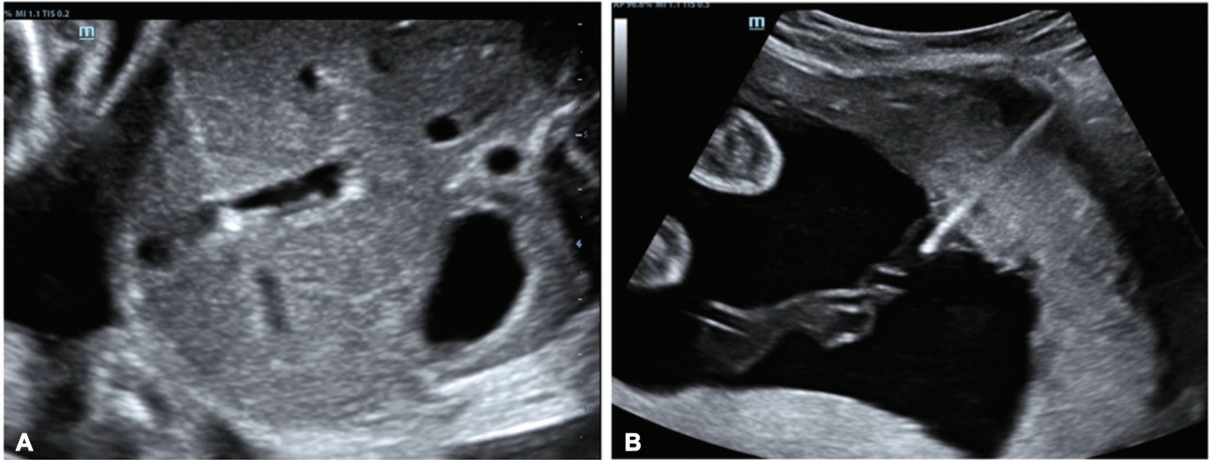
Two-dimensional grayscale ultrasound images showing the two common intravascular placements of the needle. This image demonstrates the two sites of intravascular placements of the needle for IUT. (A) Axial image of fetal liver showing the placement of needle inside the umbilical vein. (B) The needle has been guided toward the placental insertion of the umbilical vein. IUT, intrauterine transfusion.
